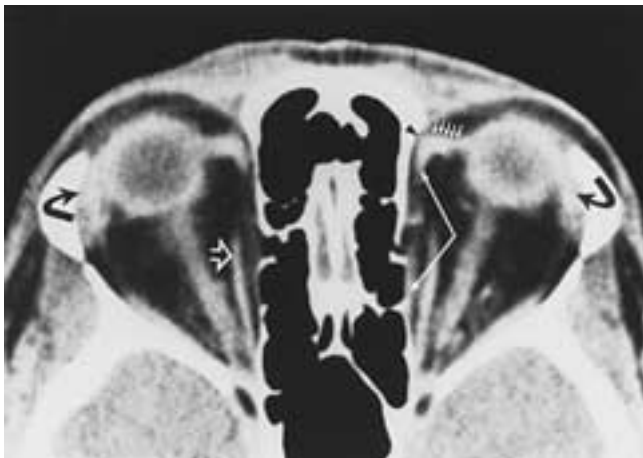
Normal superior oblique muscles. Axial CT scan demonstrates the superior oblique tendon (*crossed arrows*); trochlea (*arrowhead*); reflected portion of the superior oblique muscle's tendon (*white arrows*); medial rectus (*hollow arrow*); and lacrimal glands (*curved arrow*). (From Mafee MF et al. CT in the evaluation of Brown's superior oblique tendon sheath syndrome. Radiology 1985;154:691–695.)
